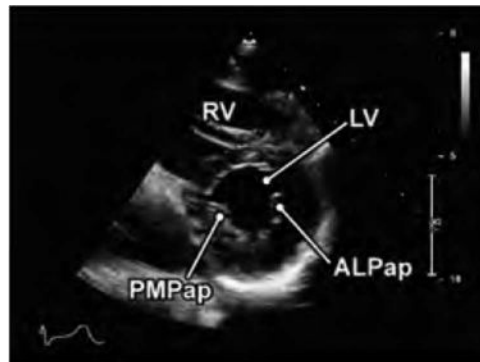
The parasternal short-axis (PSAX) view of the focused cardiac ultrasound (FOCUS) examination. LV, left ventricle; RV, right ventricle; PMPap, posteromedial papillary muscle; ALPap, anterolateral papillary muscle (figure courtesy of Elaina Lin).
